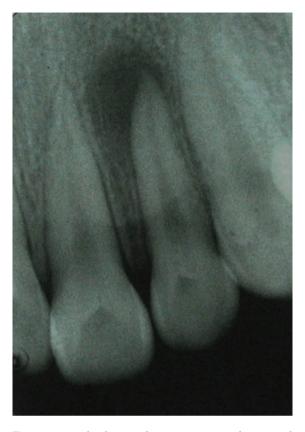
Example of type II dens invaginatus with periapical lesion.
